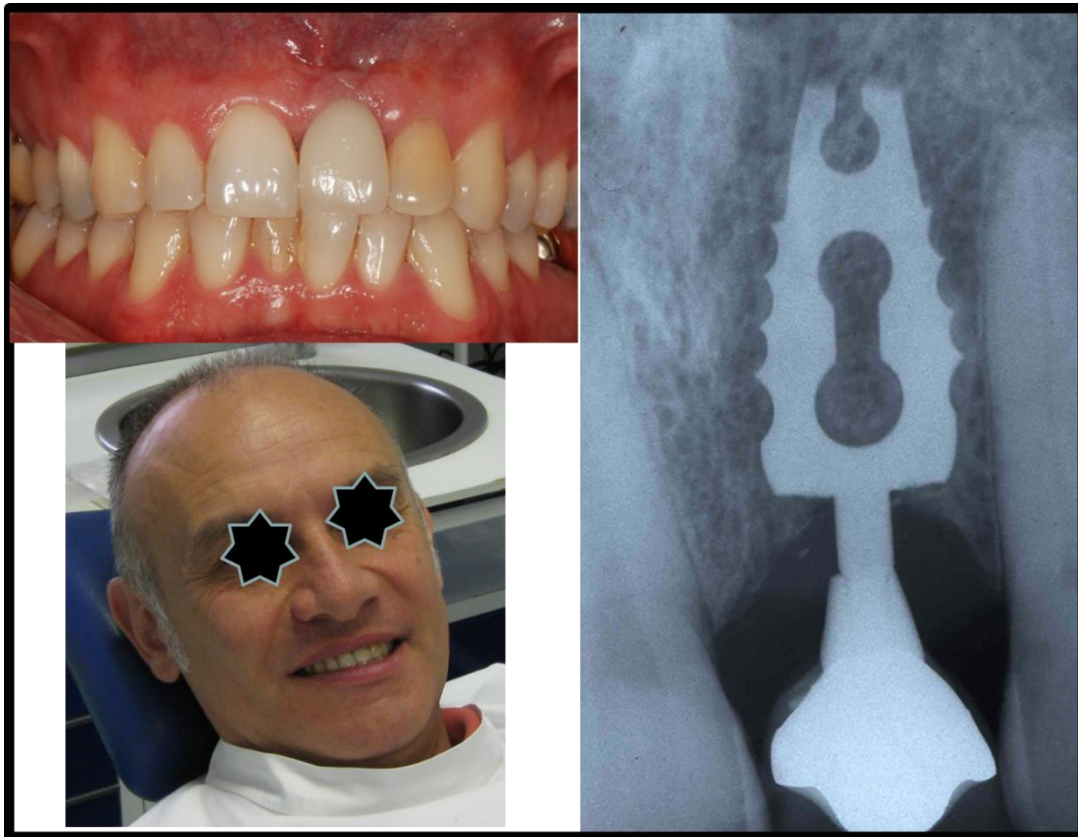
Loss of the upper left central incisor in a 16 year old boy (1972). X-ray of the inserted blade*
